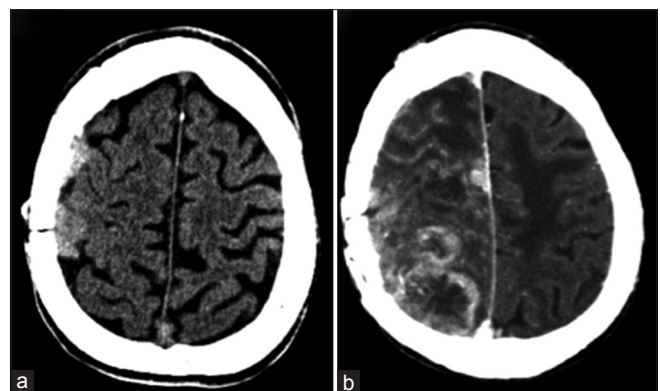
CT image indicating right frontal convexity meningioma (a). Follow up ct scan with contrast indicating recurrence of the tumor (b)
